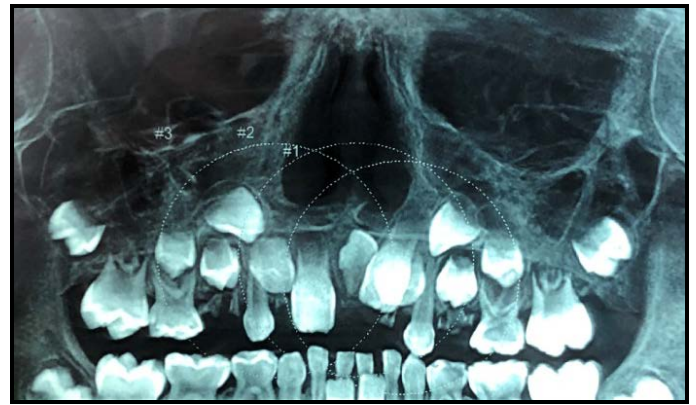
Presence of Mesiodens in CBCT
